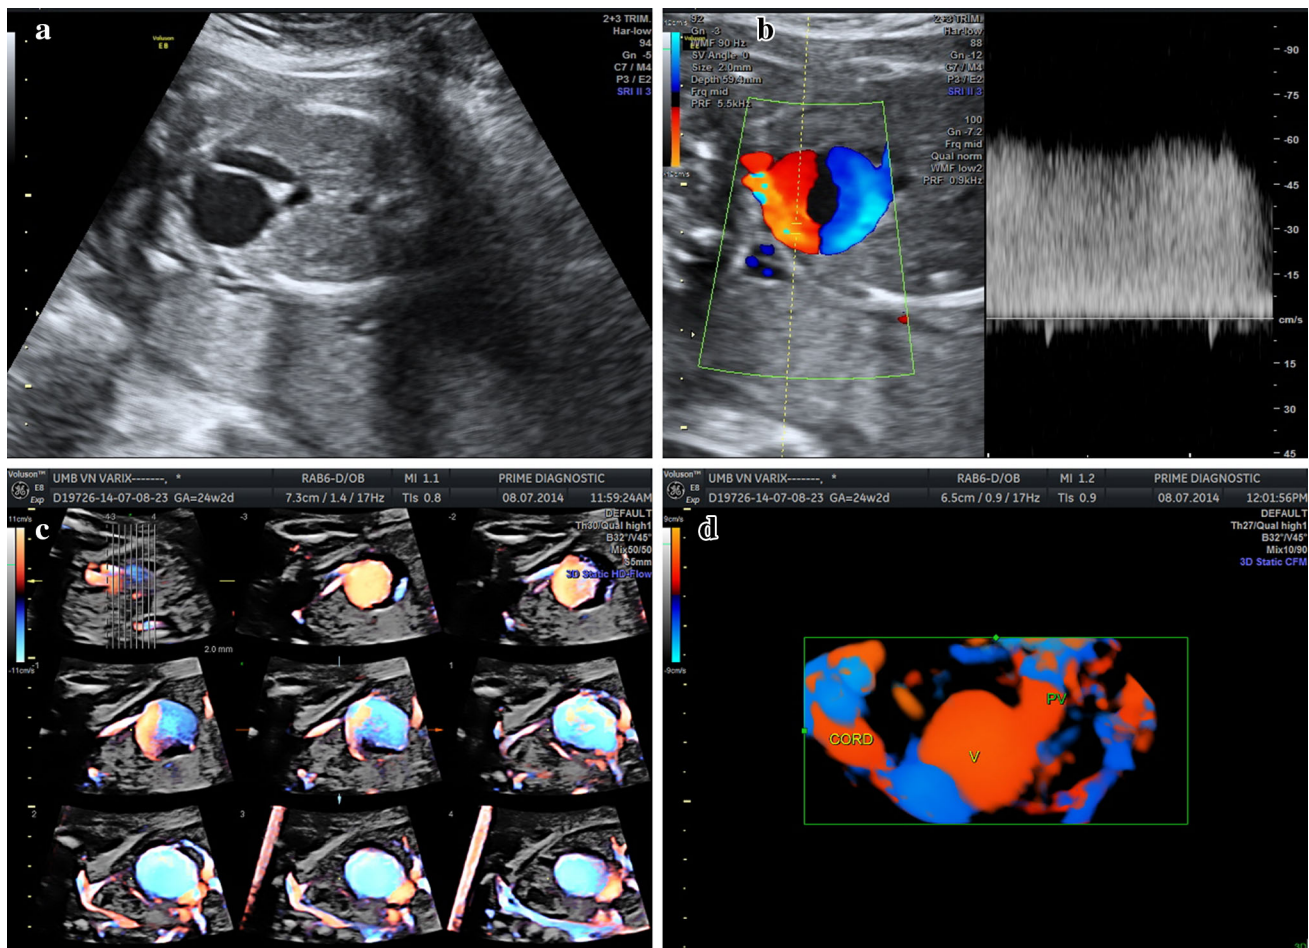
a B-mode axial ultrasound of the fetal abdomen at 24 weeks showing a large anechoic lesion in the abdomen in relation to the umbilical vein. b Color Doppler showing spontaneous continuous flow
